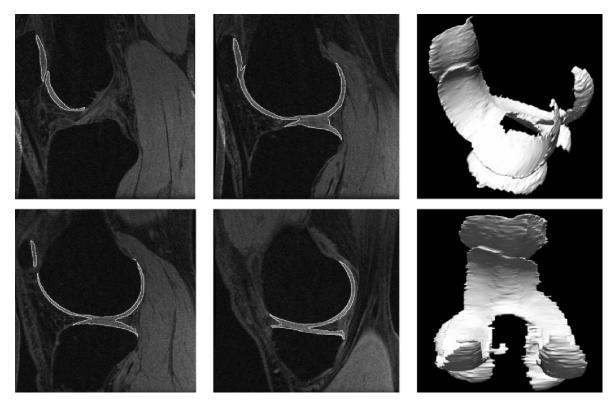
Cartilage volume segmentation on MRI.
